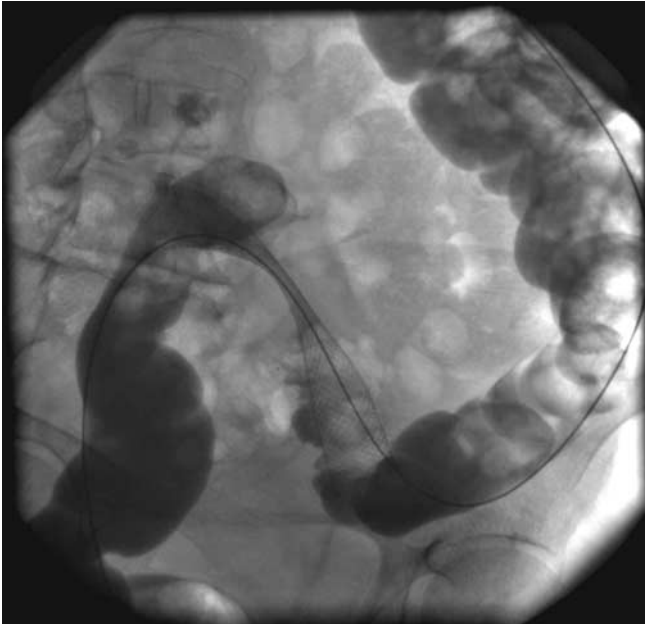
X-ray image of stent in obstructive sigmoid neoplasia during expansion
